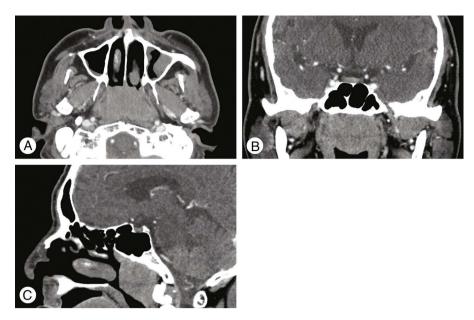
Computed tomography (CT) of paranasal sinus. Contrast-enhanced CT images show a bilateral, homogenous, mildly-enhanced solid mass from nasopharynx extending to upper oropharynx on axial (A), coronal (B), and sagittal (C) view.
